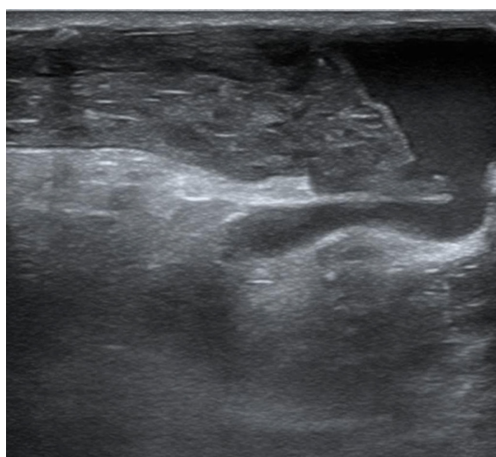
Ultrasonic image of the anastomotic stoma before thrombolysis.
